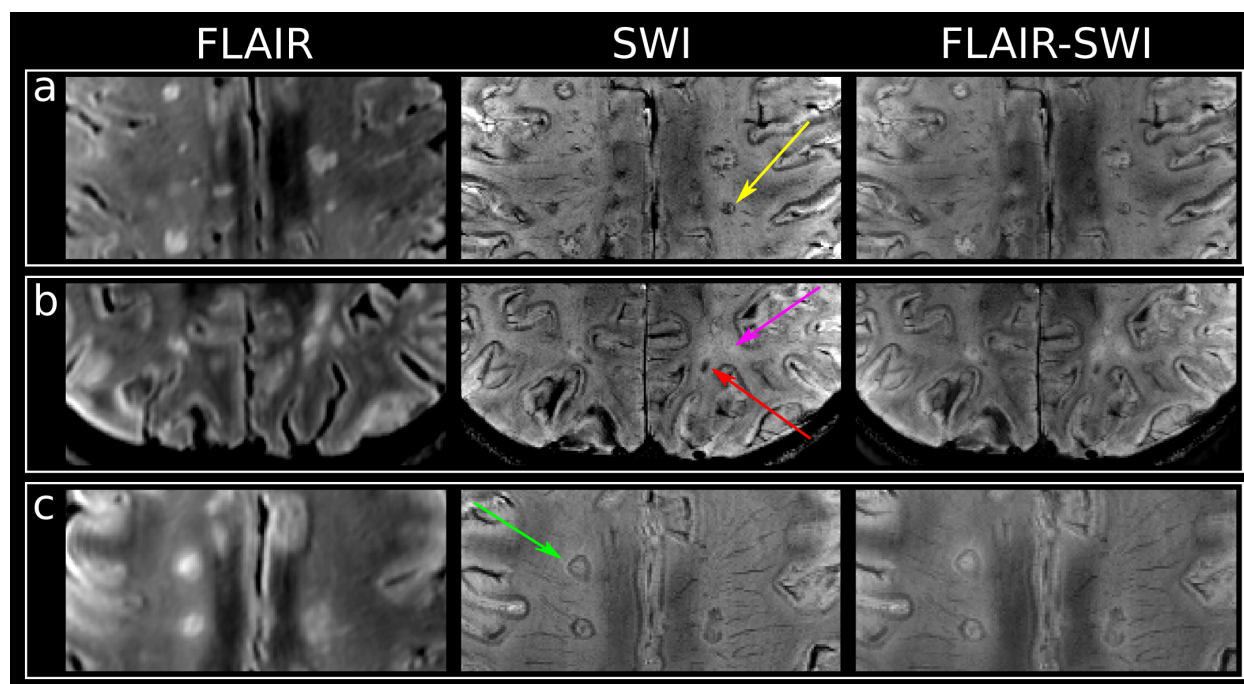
T2-FLAIR, SWI, and overlaid FLAIR-SWI images of (a) lesions categorized as “transition” with yellow arrow pointing toward an example, (b) “area” iron deposition indicated by a red arrow, “non-iron” indicated by a pink arrow, and (c) “rim” lesion with an iron rim indicated by a green arrow.
